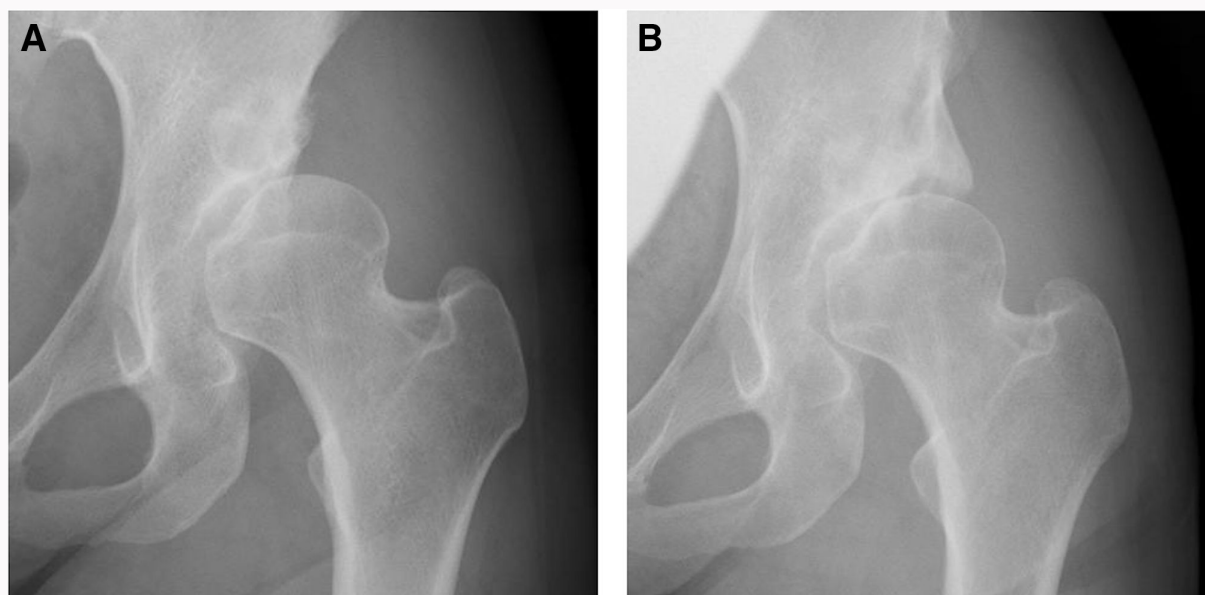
Radiographs of a 44-year-old female who had undergone a modified Spitzzy shelf acetabuloplasty on the left hip: a) preoperatively, osteoarthritis Tönnis grade 2 with bone cyst, a lateral centre-edge angle of 0° (Merle d'Aubigné clinical score, 8 points), and b) at 12 years postoperatively, osteoarthritis Tönnis grade 2, a lateral centre-edge angle of 35° (Merle d'Aubigné clinical score, 16 points).
